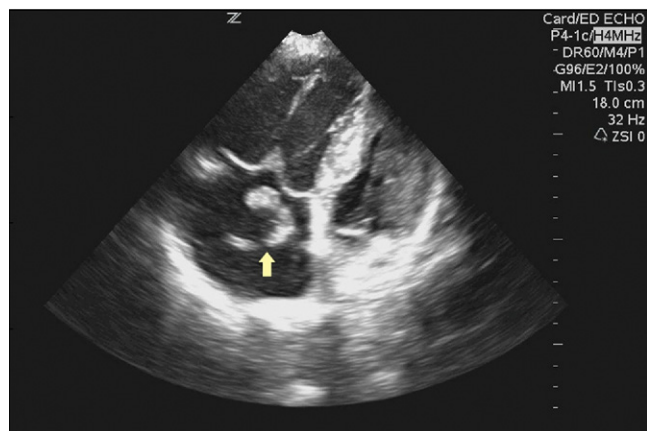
Echodense structure visualized in the right atrium on apical 4-chamber view.
